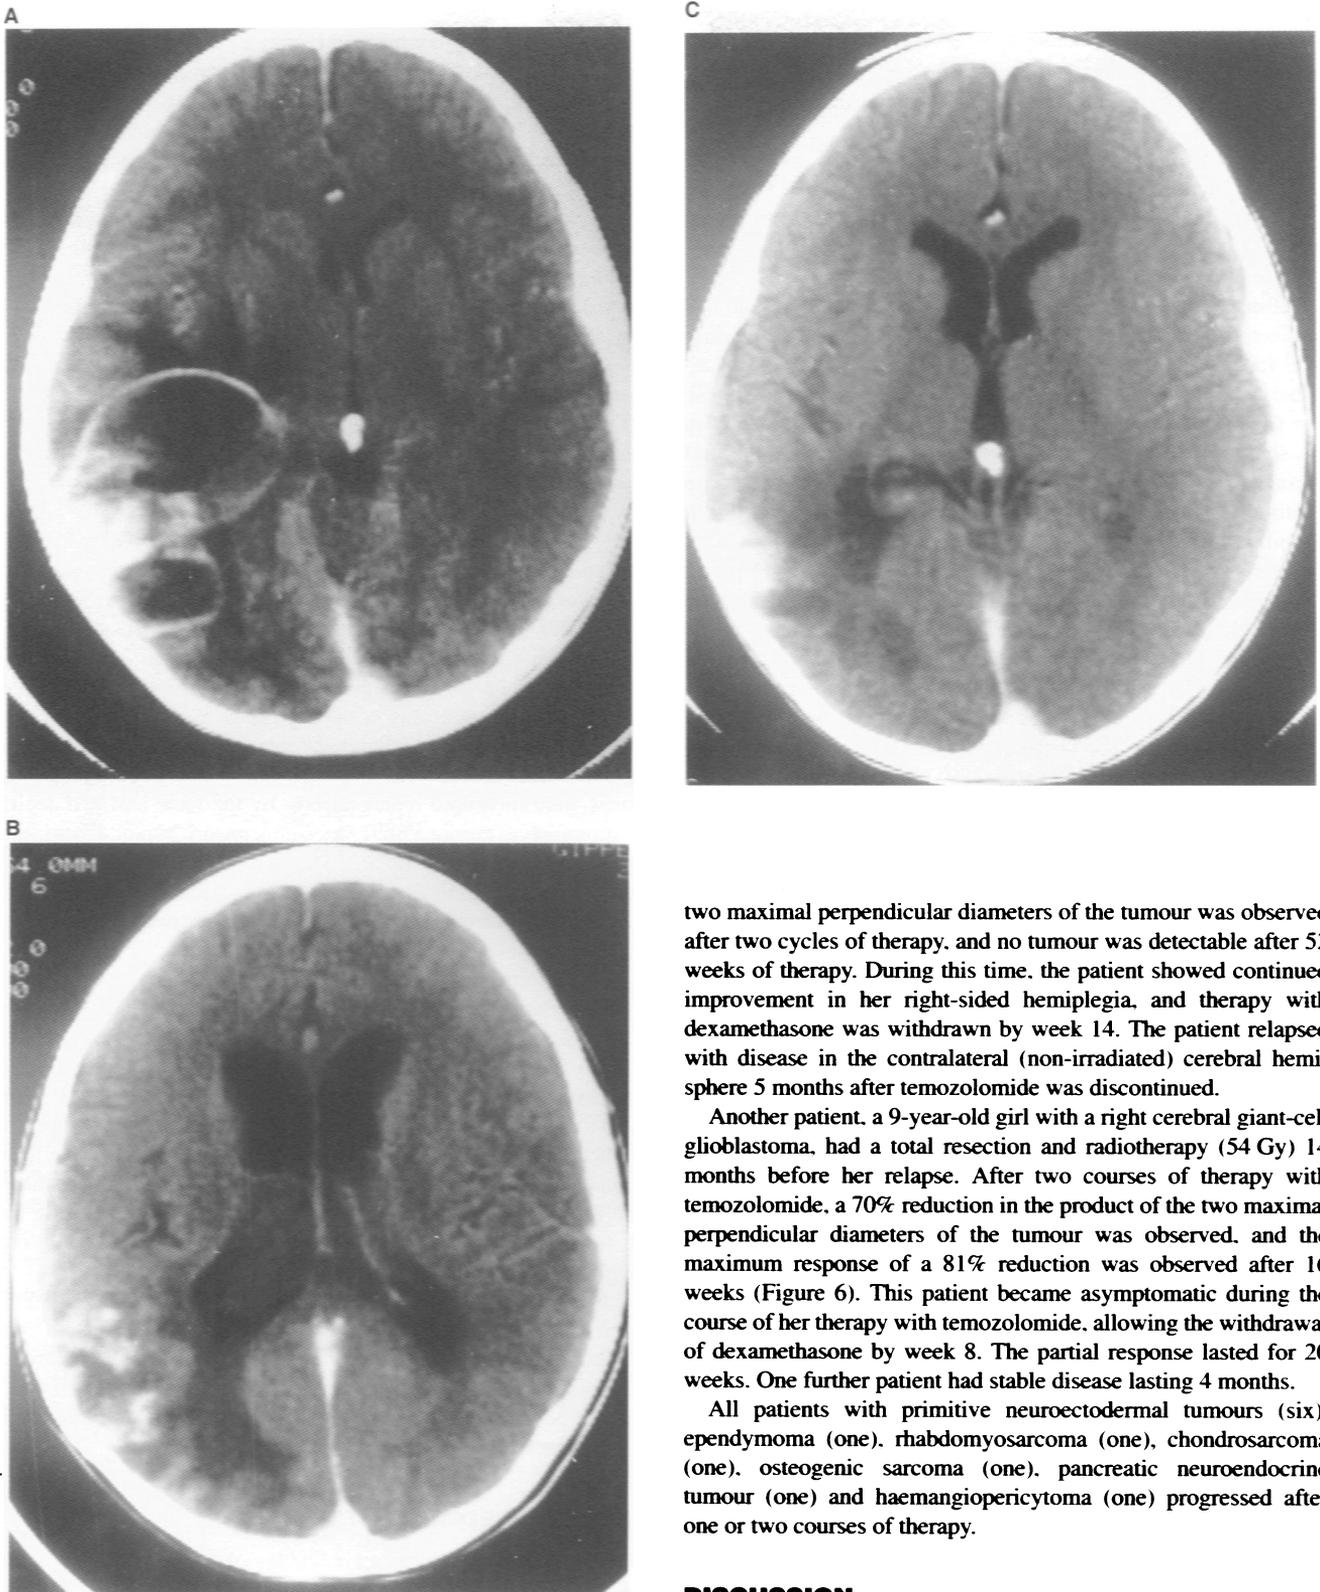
Response to therapy with SCH 52365 as imaged by CT scan. A was taken at relapse, B after two courses of SCH 52365 (partial response) and C at the time of maximal response (at 17 weeks), in a 9-year-old girl with a glioblastoma, which recurred 62 weeks after total excision and radiotherapy
